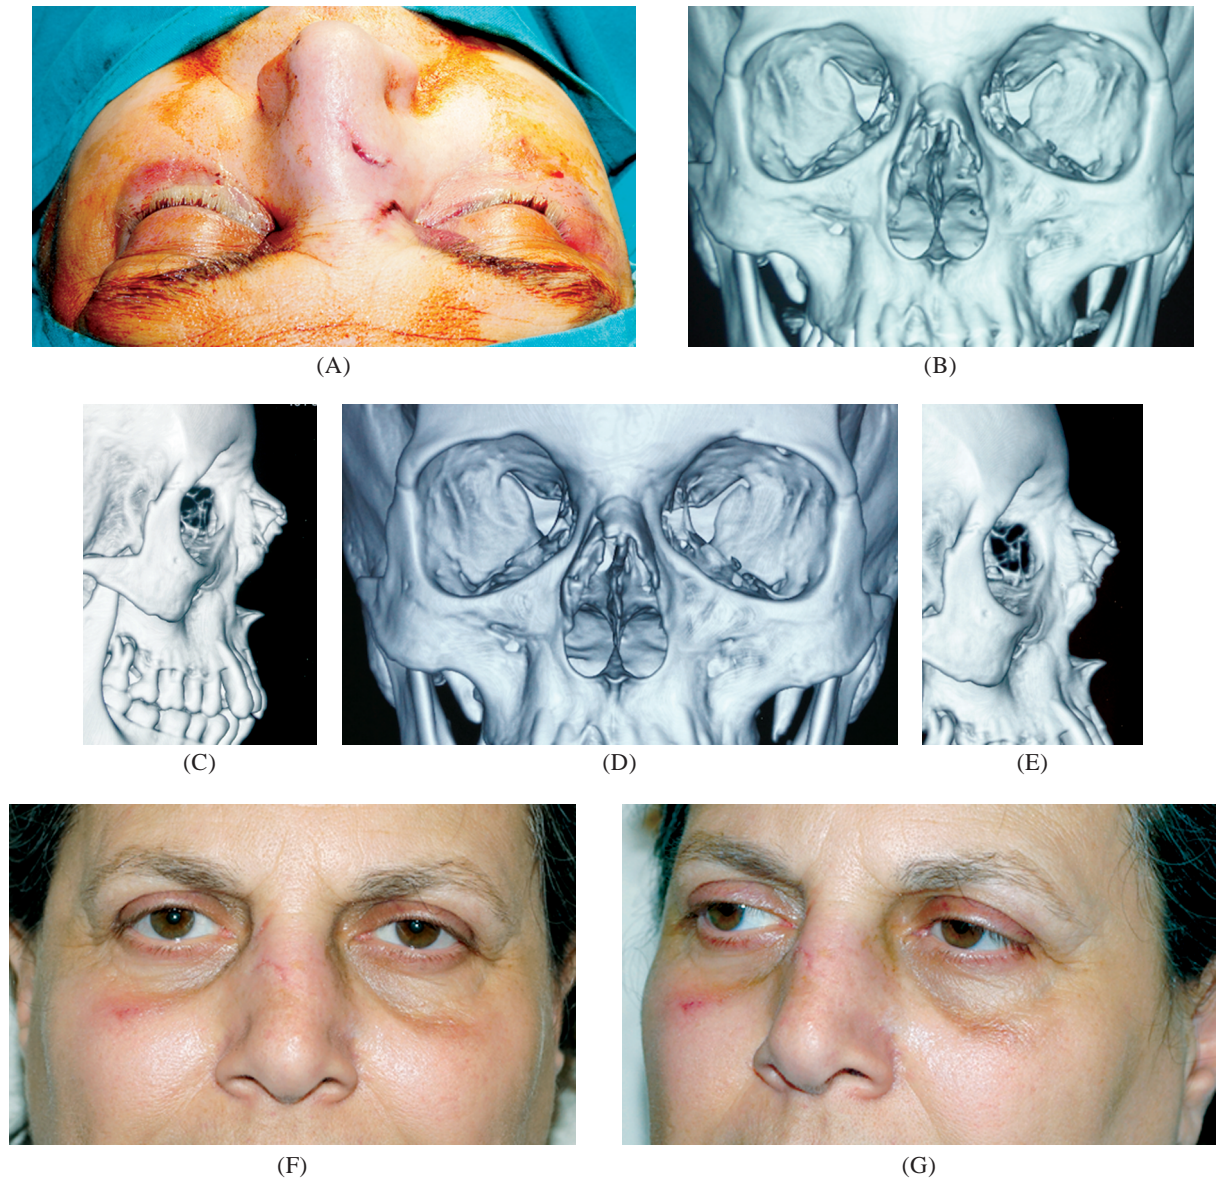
A 40 years old male patient who presented a direct blow causing Rt. Nasal bone fracture. (A) shows the pre-operative deformity after the blow with deviation to the left, (B&C) showing pre-operative 3D CT Scan of the Fracture, (D&E) showing post-operative 3D CT Scan with non-anatomical thus acceptable result, (F&G) showing the same patient three weeks post-operatively, anterior and oblique views.
